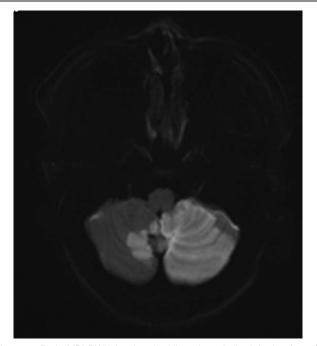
Brain MRI DWI showing the bilateral cerebellar infaction (arrow). DWI=diffusion-weighted imaging, MRI=magnetic resonance imaging.
